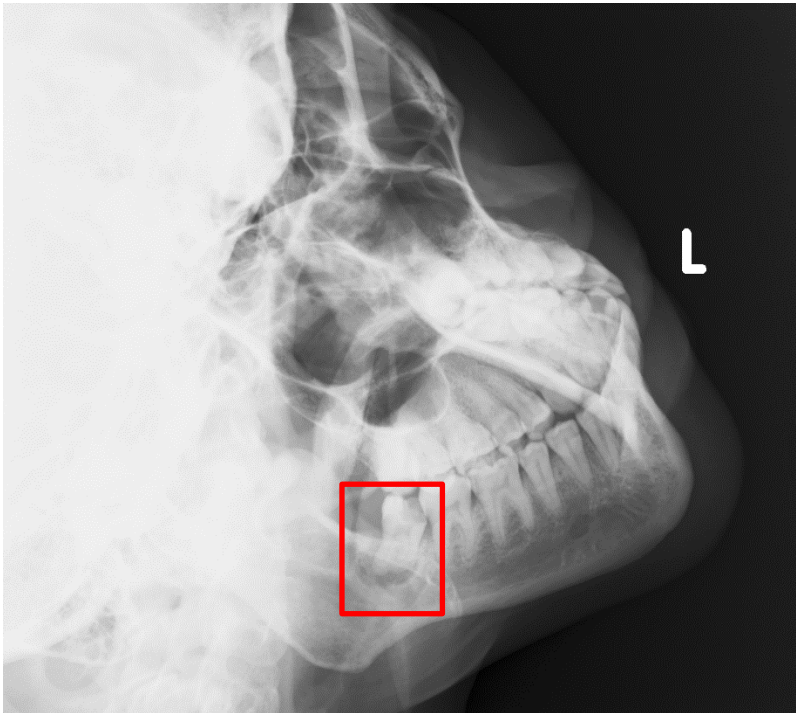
Periapical radiolucent lesion on impacted M3 on left
